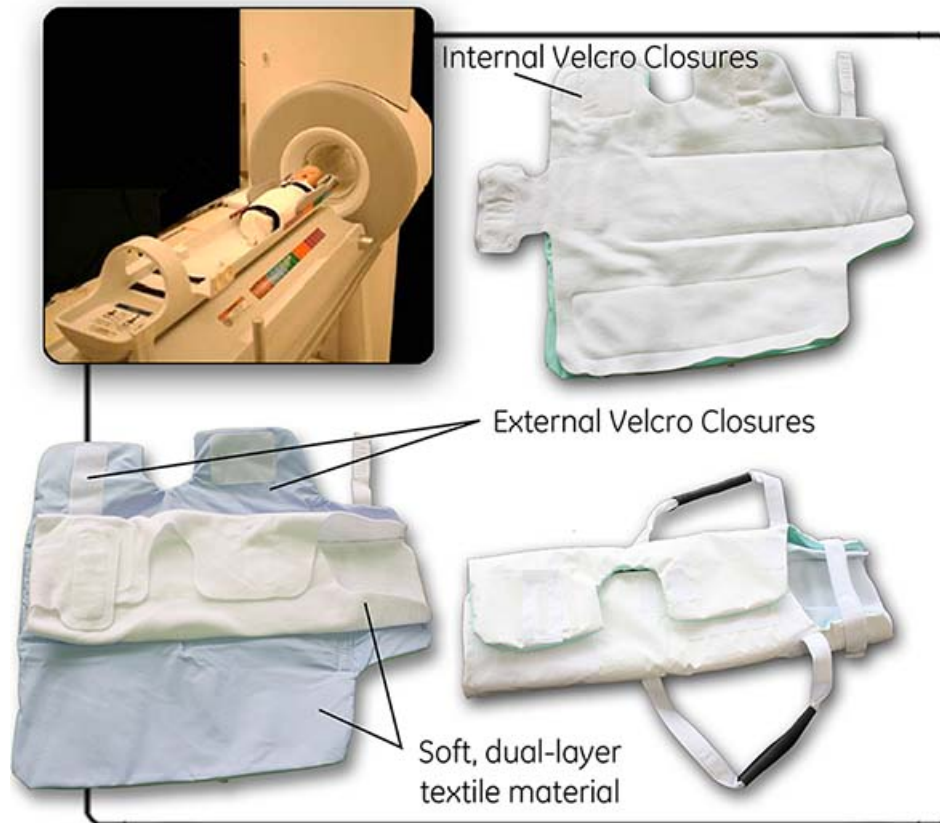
Image of swaddled neonate entering the 3.0T Neonatal MRI investigational device bore (*top left*) and views of soft, dual-layer textile swaddles showing Velcro® closures
